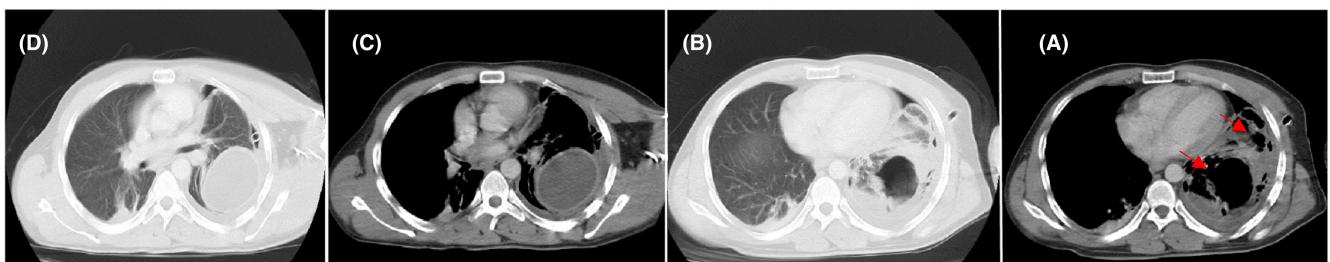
CT with axial sections scan of the chest. (A) An axial-section in the Mediastinal window shows signs of the ruptured cyst (air inside) and signs of empyema (air bubbles with the red arrow). (B) the same section in A with the lungs window. (C) axial -section in the Mediastinal window shows the intact cyst homogenous opacity with sharp contours with moderate density. (D) the same section in C with the lungs window.
